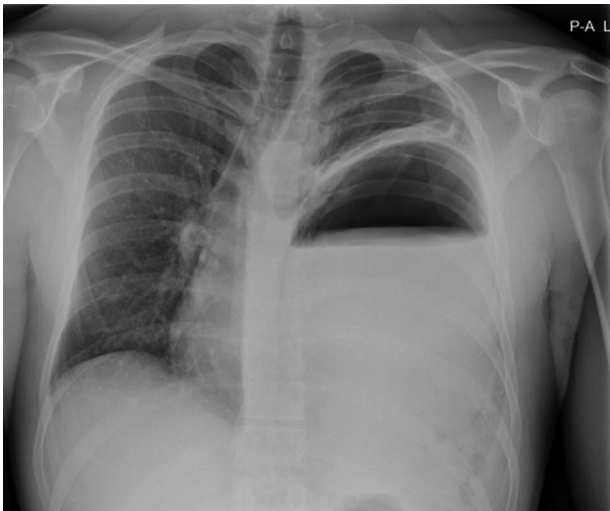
Erect chest x-ray showing almost complete atelectasis of the left lung with a large amount of fluid in the left hemi thorax and mediastinal shift to the right.
